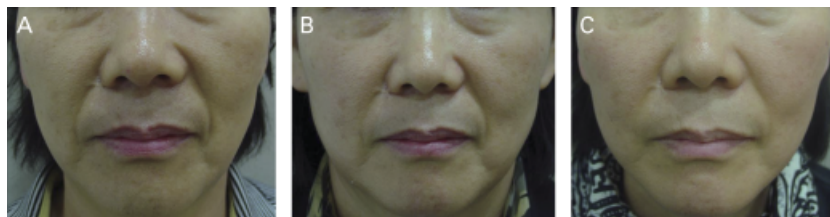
Improvement of the nasolabial fold after a single intense focused ultrasound treatment. (A) Before treatment, (B) 1 month after treatment, (C) 2 months after treatment.
